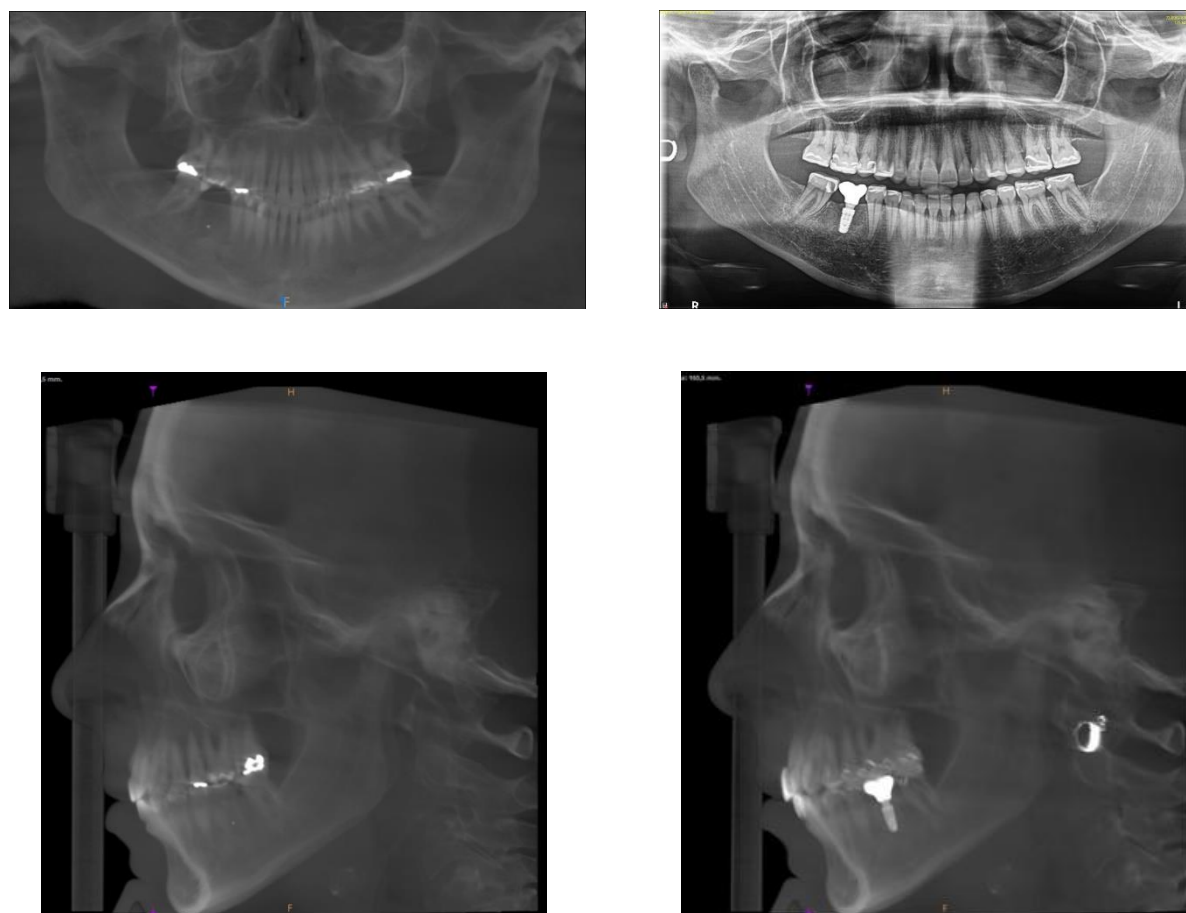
Orthopantomography and Cephalometry pre and post-treatment images.
